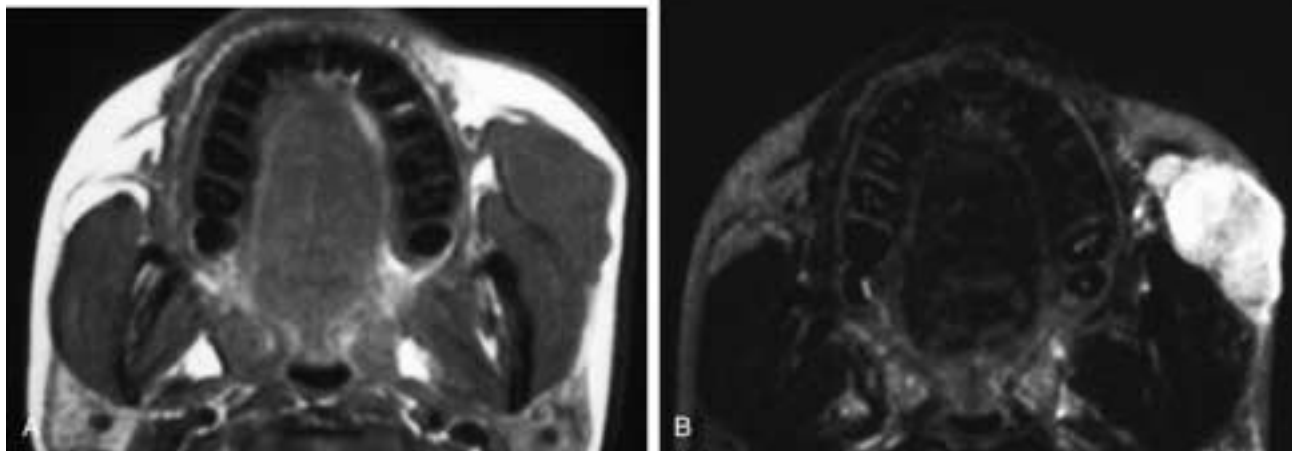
Axial T1-weighted (A) and T2-weighted (B) MR scans show a soft-tissue mass in the left cheek overlying the masseter muscle. There is slight nonhomogeneity on the T2-weighted image. Despite its size, there is relatively little mass effect, suggesting a soft lesion. Clinically, this mass was thought to arise in the parotid gland of this child. This patient had a hemangioma.
